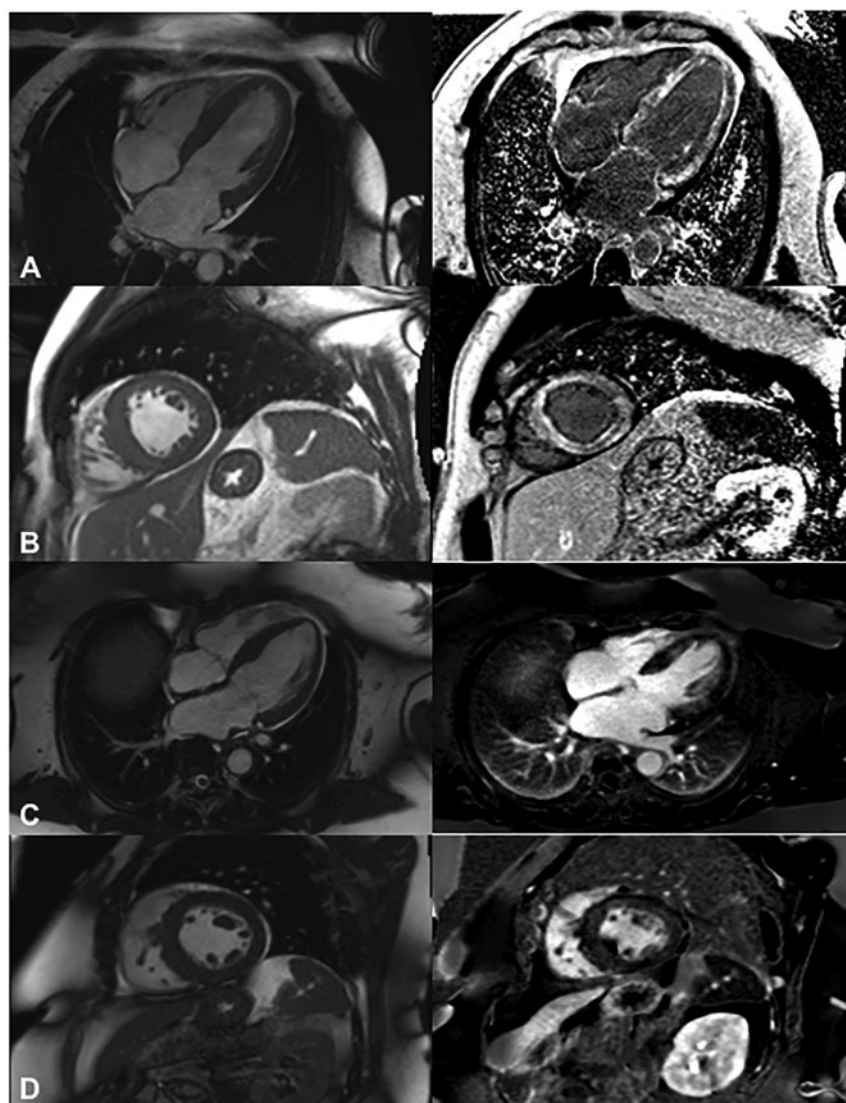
Cardiac magnetic resonance imaging of brother–sister pair with extensive fibrosis in a pattern suggestive of infiltrative disease. Left column cardiac magnetic resonance imaging with gadolinium, and right column with Phase-Sensitive Inversion Recovery of gadolinium-delayed hyper-enhancement. (A) Horizontal long axis and (B) mid-ventricular short axis views of the brother who is heterozygous for the transthyretin valine-to-isoleucine mutation with diffuse, atypical late gadolinium enhancement noted in all myocardial segments consistent with cardiac amyloidosis. (C) Horizontal long axis and (D) mid-ventricular short axis views of the sister who is homozygous for the transthyretin valine-to-isoleucine mutation showing patchy, abnormal delayed mid-myocardial enhancement extensively throughout the left ventricular myocardium also consistent with cardiac amyloidosis.
